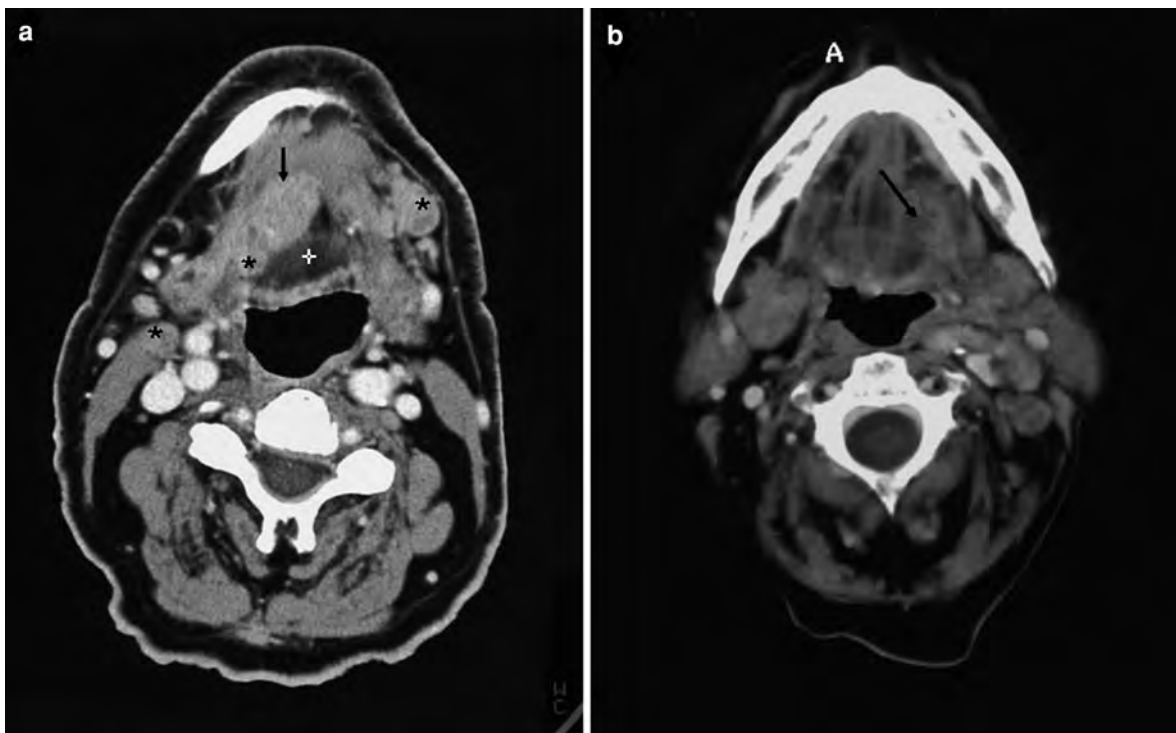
CT of 62-year-old man with a squamous cell carcinoma lying more deeply in the floor of the mouth (a). The tumor is located between the mylohyoid muscle and the partially presented transverse (intrinsic) muscles of the tongue (cross). Note the bilateral lymph node metastases. Different
